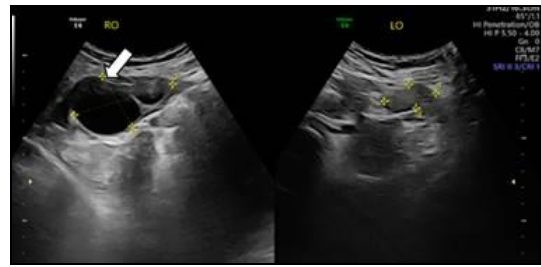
Transverse dual-screen pelvic ultrasound of both ovaries reveals a right ovarian anechoic cyst with smooth contours and posterior acoustic enhancement, likely representing a simple cyst. The left ovary appears normal with physiological follicular pattern.
